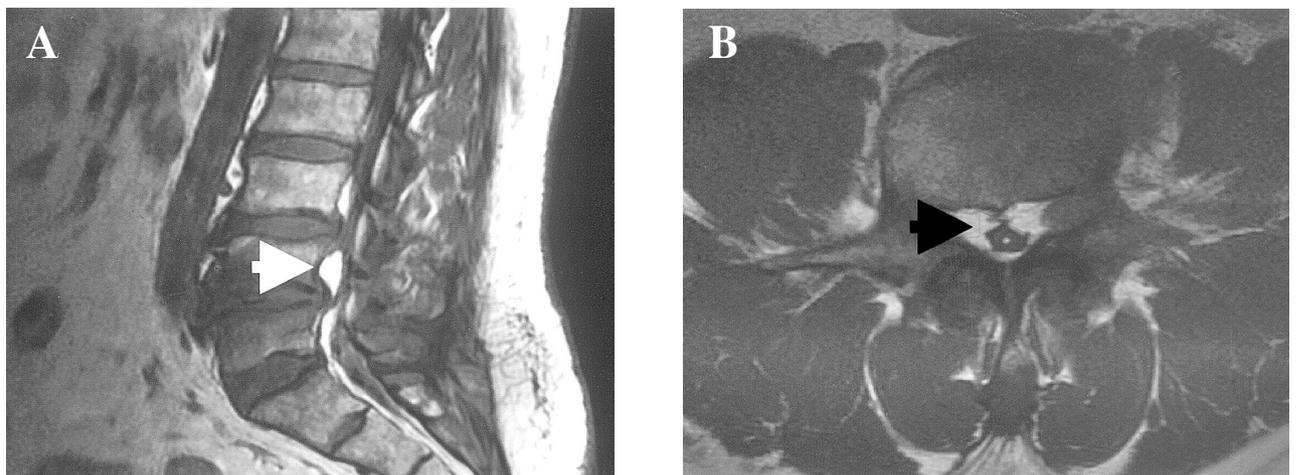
T1-Weighted MRI showed an extradural high intensity area posterior to the thecal sac at L3-L5 region (Case 2). (A) The T1-weight image revealed moderate bulging intervertebral discs at L3-4 and L4-5 level. The overgrowth adipose tissue circumferential compression of the thecal sac at L3 to L5 level (white arrow). (B) The axial view of MR image showed mark spinal canal compression by overgrowth adipose tissue. The maximal fat thickness measure 8 mm (black arrow).
